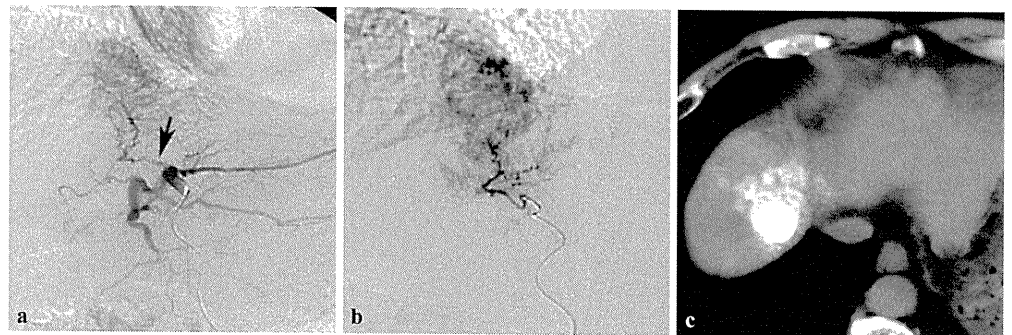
HCC in the Spiegel lobe. a Arteriogram of the left hepatic artery shows the caudate artery derived from the medial segmental artery (*arrow*). b The vessel was selected, and TACE was performed. The contour of the Spiegel lobe was seen. *Arrow* points to the tumor. c CT 1 week after TACE shows dense iodized oil accumulation in the tumor. d However, CT 13 months after TACE
